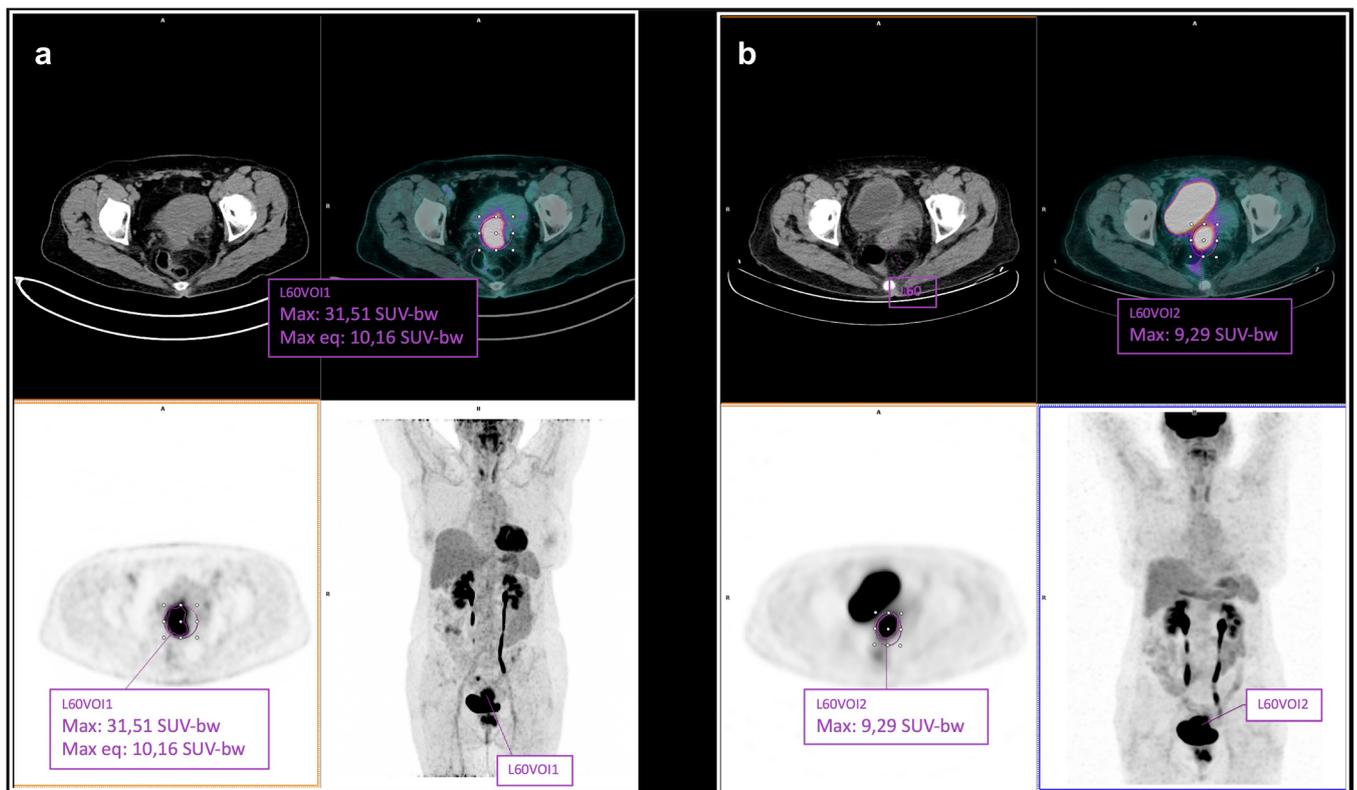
A representative case of a 68-year-old patient with locally advanced cervical cancer (squamous cell carcinoma—FIGO IIB). a Axial co-registered CT, PET, fused, and maximum intensity projection (MIP)  $[^{18}\text{F}]$ FDG PET/CT images acquired at staging on Biograph mCT scanner showing intense uptake in the cervix lesion (target) with no evidence of lymph nodal or distant metastases. b Axial co-registered CT, PET, fused, and MIP  $[^{18}\text{F}]$ FDG PET/CT images after concomitant chemo-radiotherapy on GXL scanner, showing the persistence of intense uptake at the target lesion. Semi-quantitative analysis demonstrated a reduction in SUVmax between the scans of 31.8 % (partial metabolic response according to EORTC criteria), classifying patient as a responder. Applying EQ-PET harmonization at baseline Biograph PET, the reduction in SUVmax was only 8 % (stable metabolic disease), changing the metabolic classification from a responder to a non-responder. A subsequent MR exam showed stable disease; the patient developed disease progression 8 months later.
